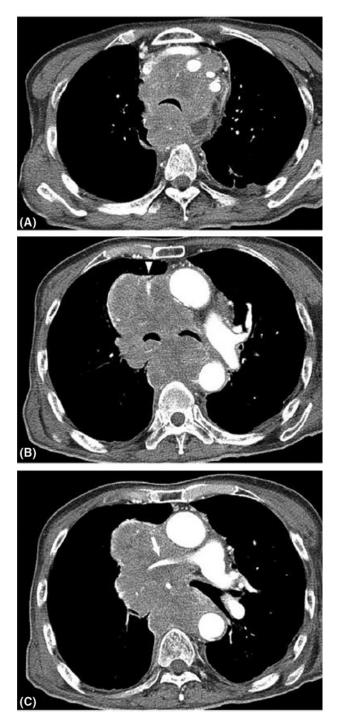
A 61-year-old female with SCLC (Type IIIc). (A–C) Axial CT mediastinal images show extensive bilateral mediastinal conglomerate mass, which are reliably distinguished from enlarged lymph nodes. This single mass is encasing and compressing the trachea to mainstem bronchi and invading the superior vena cava (B: white arrowhead) and the right main pulmonary artery. Reproduced with permission from Lee D, Rho J, Kang S, Yoo K, Choi H. CT findings of small cell lung carcinoma. *Medicine (Baltimore)*. 2016;95(47):e5426 (Figure 4). doi:10.1097 /md.00000000005426.
